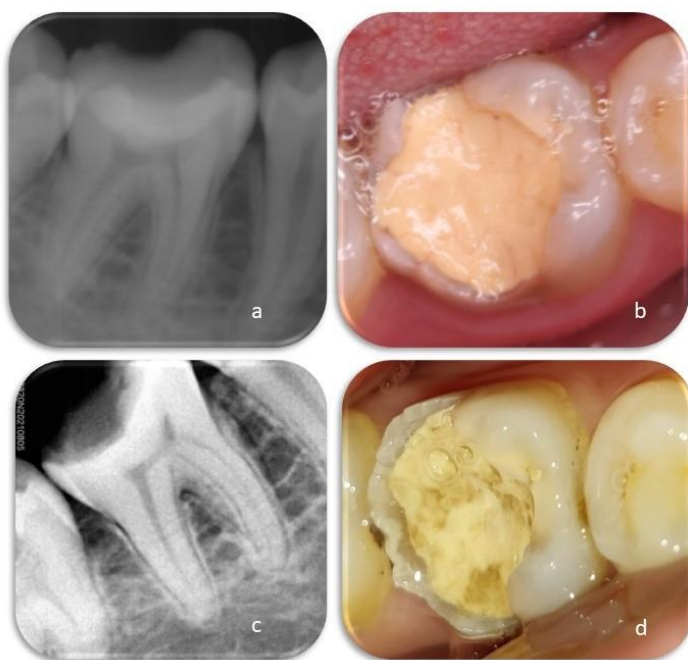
Follow-up of a Biodentine application in tooth 46, which suffered from severe and deep caries. Radiographically, no pathology was seen after 12 (a) and 33 (c) months. Although poor enamel wall support (b), the biodentine filling remained intact after 12 months(b). After 33 months, disintegration of the filling was seen but still covering the dentine (d).
